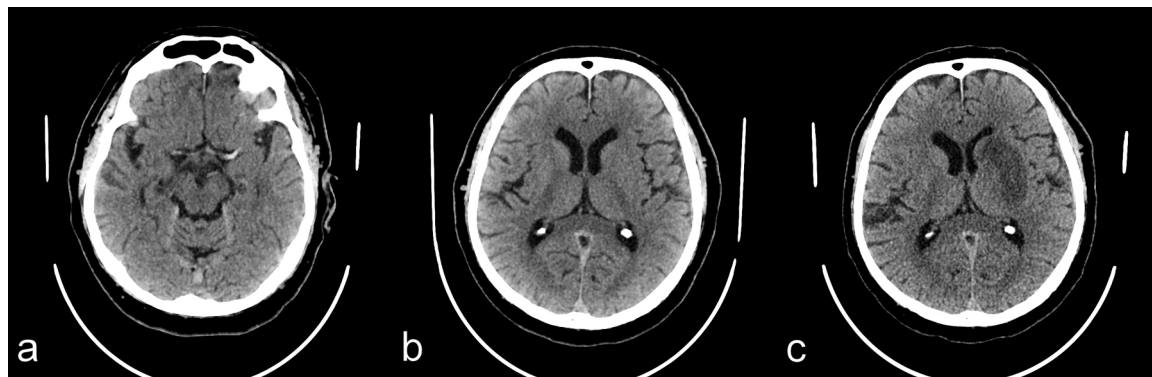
(a) Admission CT – HMCAS, (b) admission CT – no early signs of brain tissue ischemia, (c) next-day follow-up CT – infarct confirmed.
